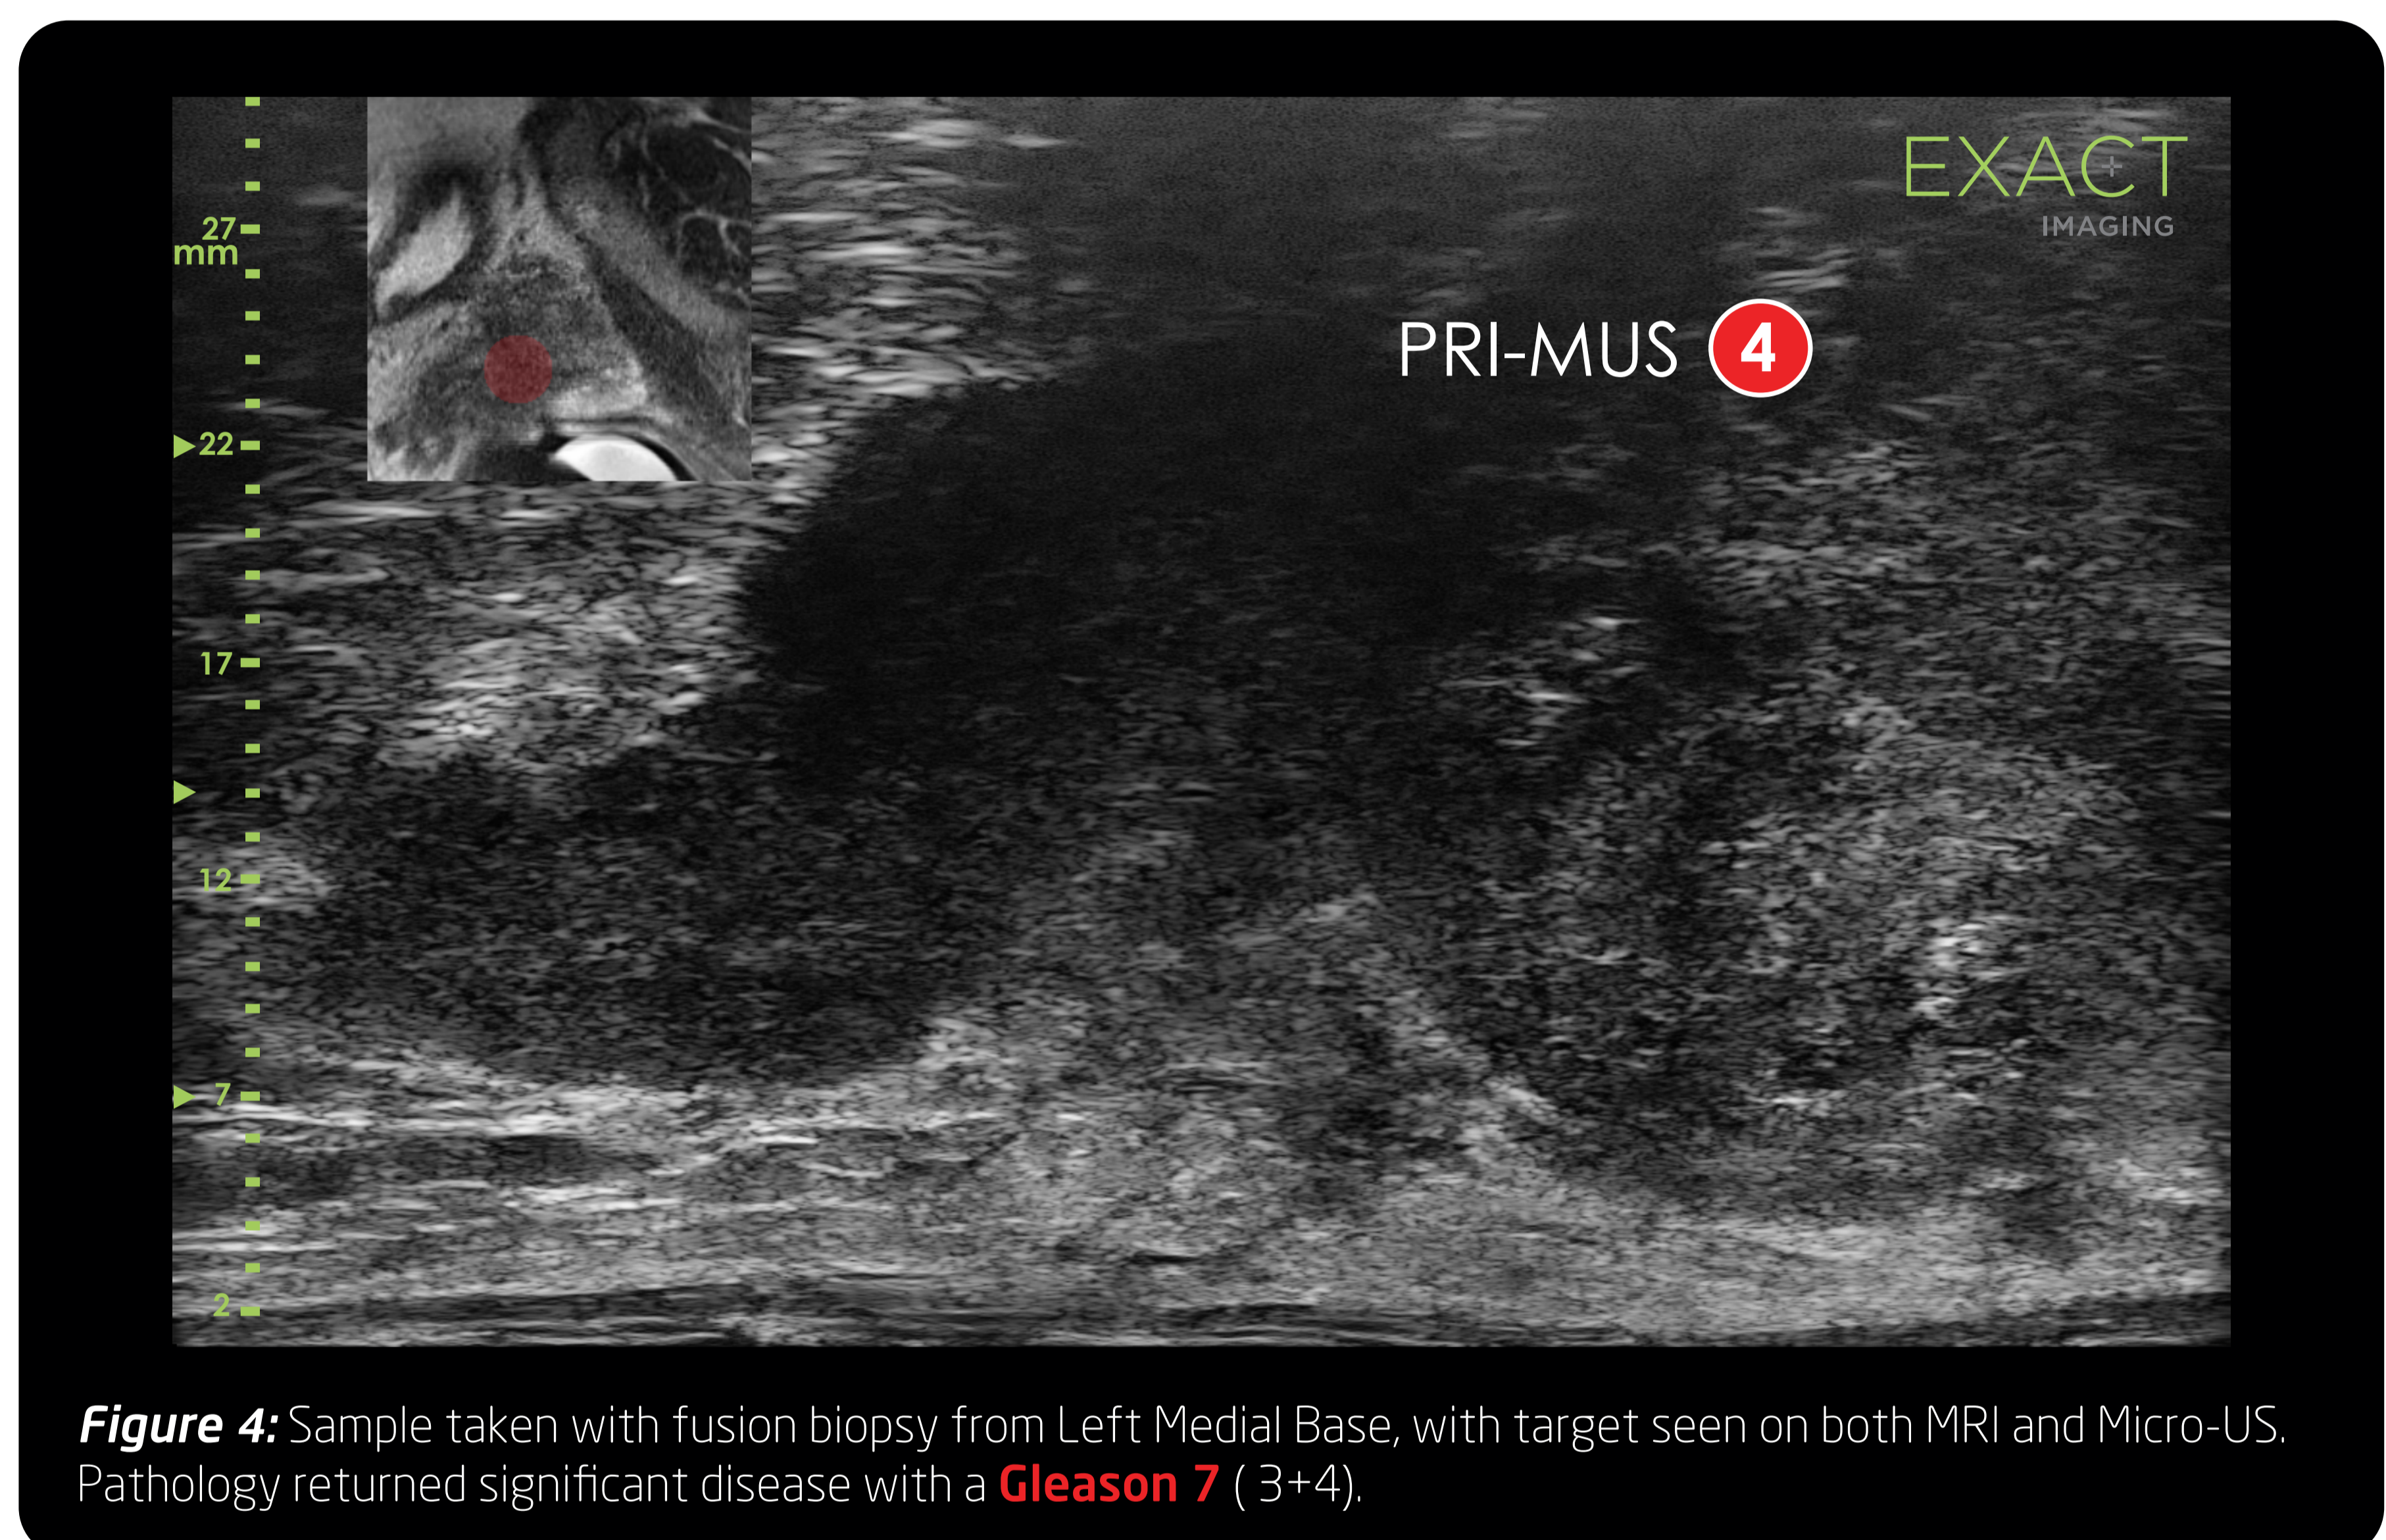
Sample taken with fusion biopsy from Left Medial Base, with target seen on both MRI and Micro-US. Pathology returned significant disease with a Gleason 7 (3+4).
